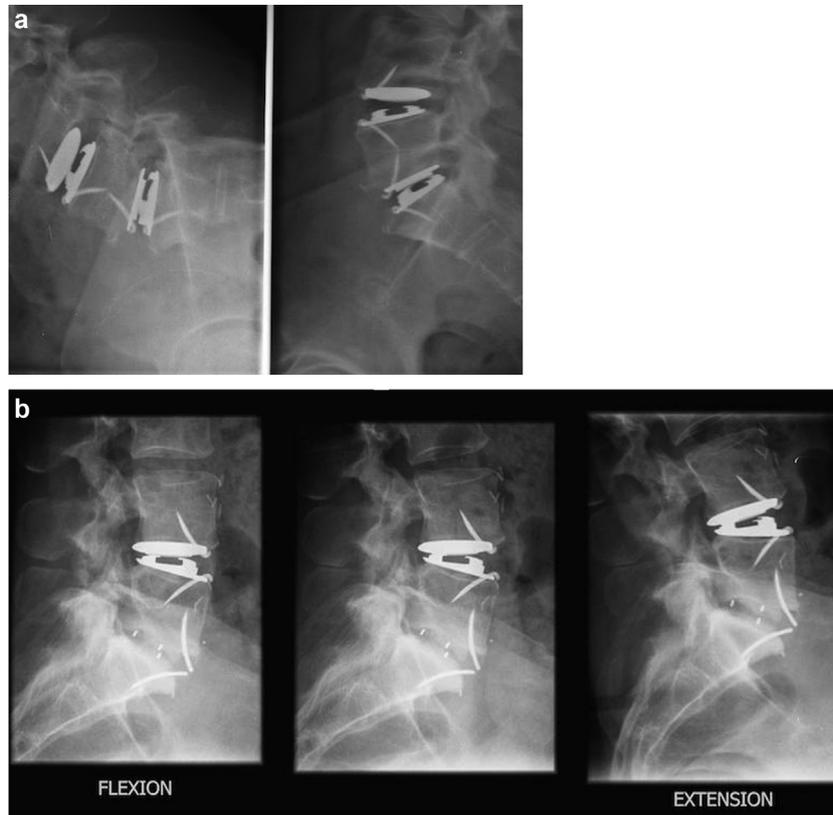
X-ray control for range of motion study: a: two-level disc arthroplasty in maximum flexion and extension; b: hybrid construct, disc arthroplasty on top of an anterior arthrodesis.
